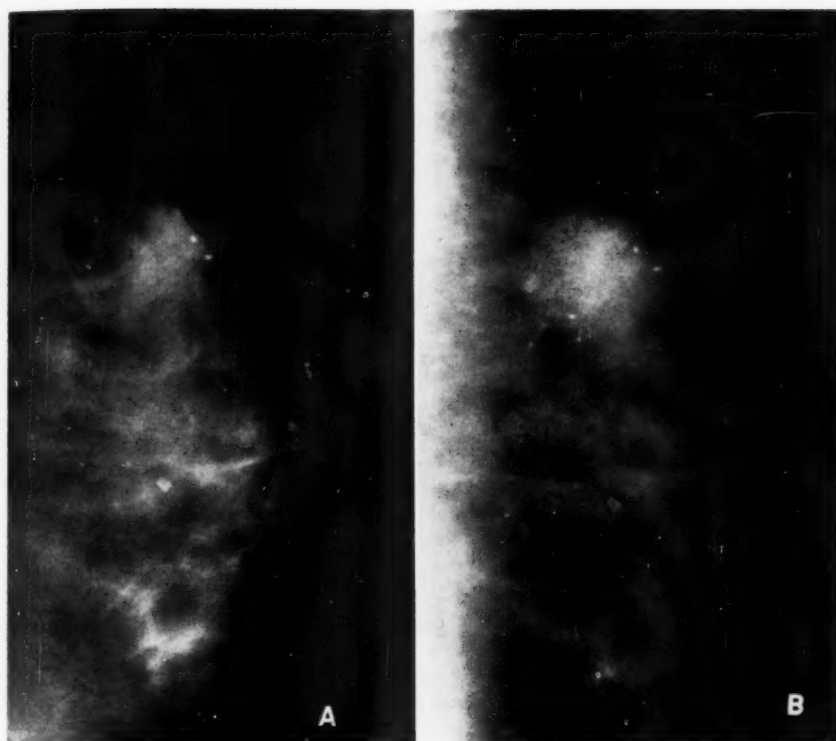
Fast growth of a scirrhus carcinoma in a patient of 45 years. She was examined radiographically at time of admission for a nipple discharge from the right breast; no palpable lesion in either breast was detected by the surgeon or in the radiological department.
